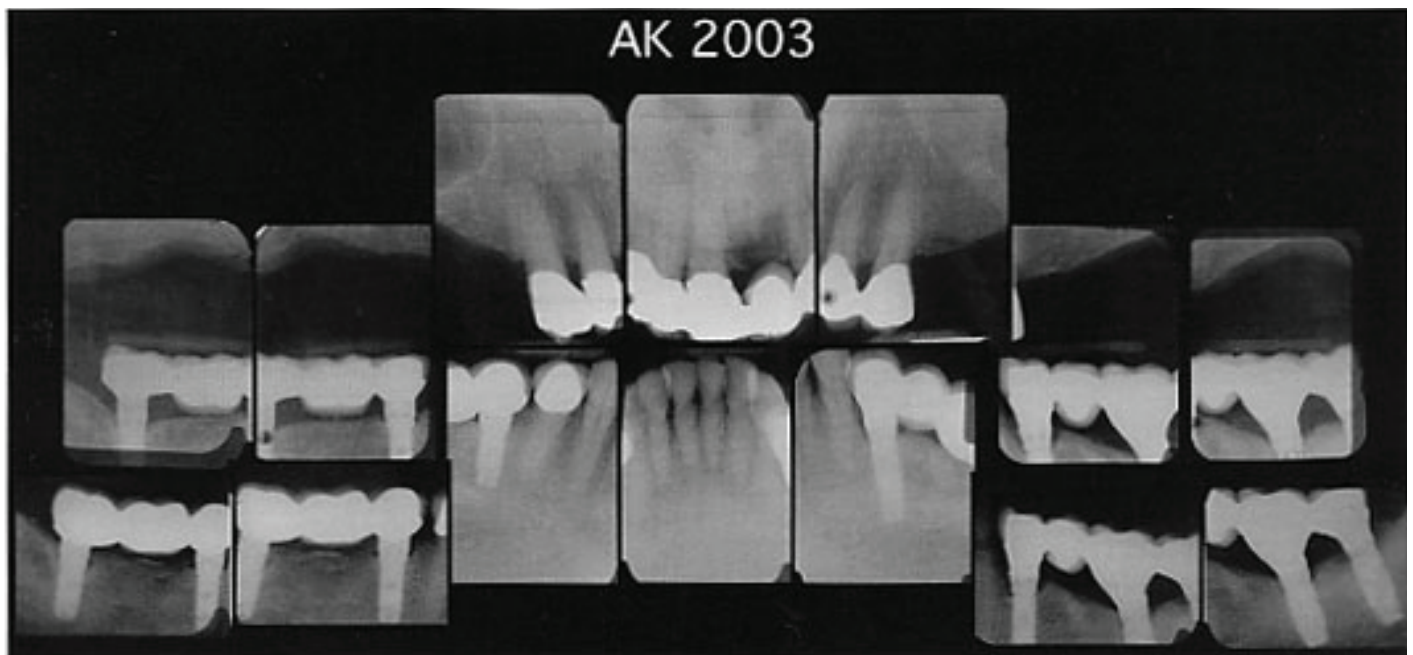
Full-mouth X-rays, 2003.
